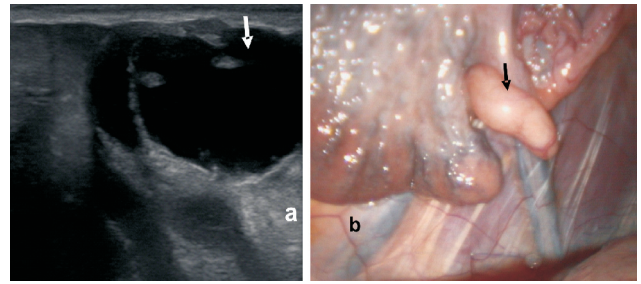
Hydrosalpinx (arrow). (a) Ultrasound image (b) Laparoscopic image.
